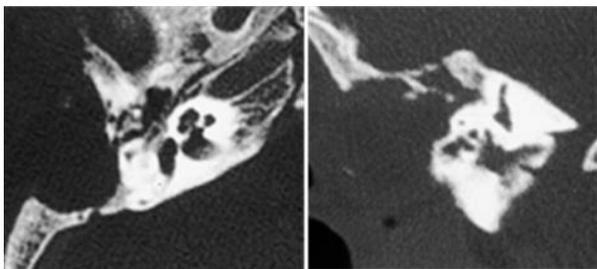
Tuberculous otomastoiditis with parenchymal abscess. (a) axial section (b) coronal cut CT scan right temporal showing middle ear destruction
